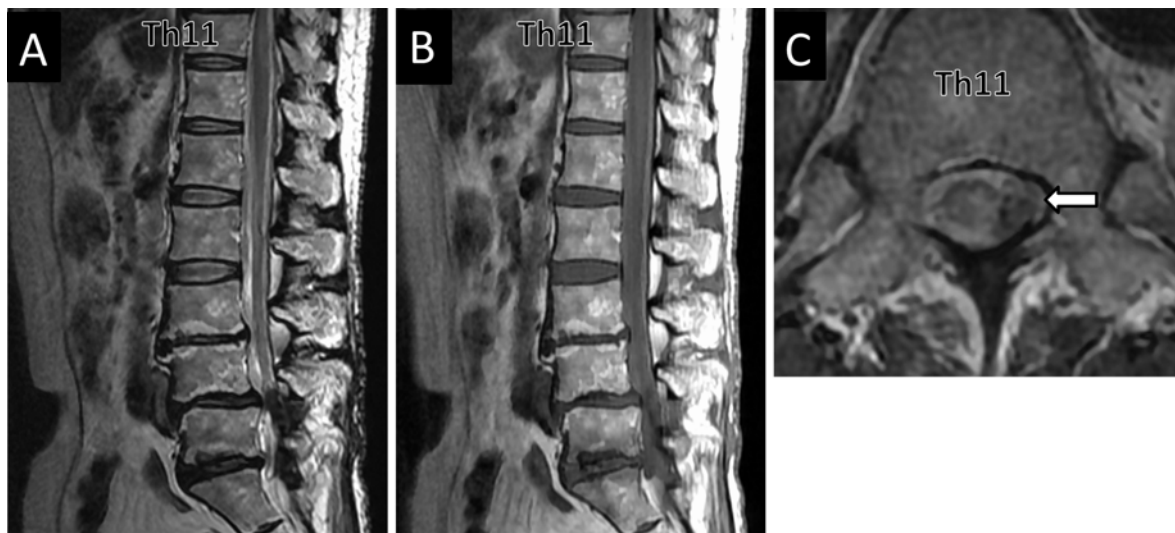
MRI performed the day after B-RTO. A: In T2-weighted sagittal image, the CSF signal within the dural sac is heterogeneous. Incidental lumbar spinal canal stenosis is noted at the lower lumbar level. B: In T1-weighted sagittal image, the CSF signal dorsally increases, with poor contrast with the spinal cord. C: T2-weighted axial image shows a crescent-shaped low-signal subdural hematoma in the dural sac with spinal cord deviation (white arrow).
